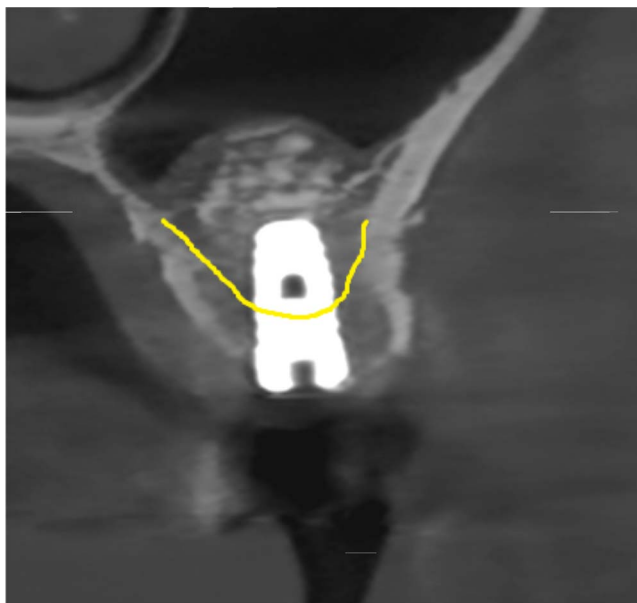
Cone beam computerized tomography cross-section following implant placement (yellow line indicating pretreatment sinus floor position).
